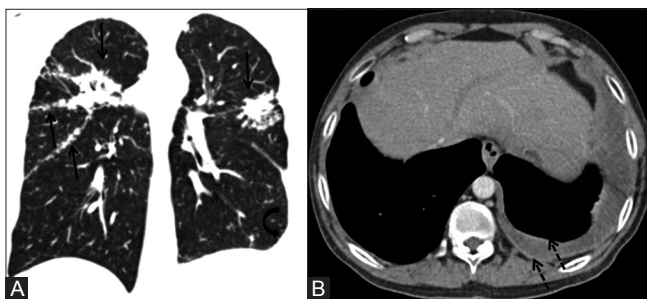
(A and B): Sarcoidosis with pleural involvement. (A) Coronal multiplanar reconstruction (MPR) image (lung window) of a patient with sarcoidosis shows typical perilymphatic nodules along interlobar fissures and subpleural interstitium with upper lobe predominance (black arrows). Note left sided pleural effusion (curved arrow) (B) Axial contrast-enhanced CT (CECT) image (mediastinal window) shows left-sided pleural effusion with mild pleural thickening and enhancement (dashed arrows). Pleural fluid analysis revealed low adenosine deaminase (ADA) level. Pleural biopsy was performed which showed non-necrotizing granuloma. The effusion subsequently resolved on treatment
